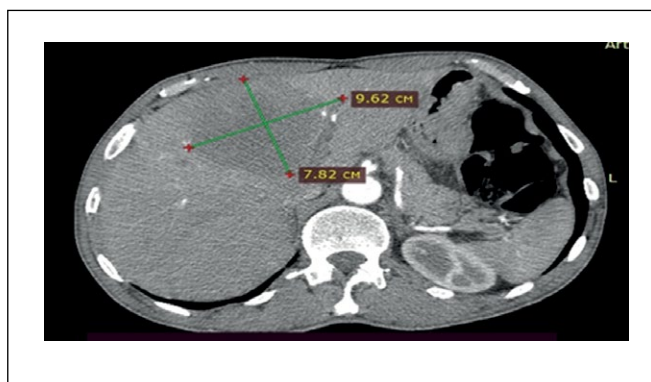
Computed tomography. Metastasis focus in the left lobe of the liver (indicated by arrows).
